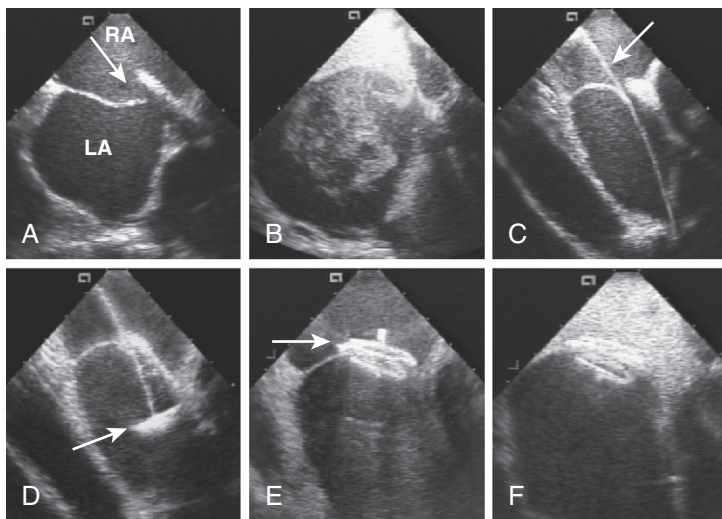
Intracardiac echocardiographic images in a young patient who has a patent foramen ovale (PFO), demonstrating the steps of closure. A, Septal view demonstrating the PFO (arrow) and the thin septum primum. B, Contrast bubble study demonstrating significant right-to-left shunt. C, Guidewire (arrow) positioned through the defect into the left pulmonary vein. D, Deployment of atrial disc (arrow). E, Deployment of the right atrial disc (arrow); release of the device. F, Contrast bubble study repeated after the device has been released, demonstrating successful closure.
